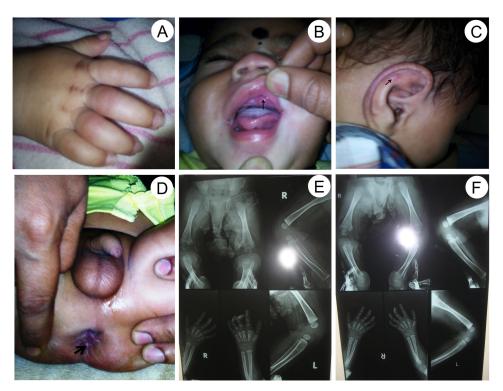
Images of different regions affected in infantile hyalinosis in identical twins. (A) showing Progression of joint contractures in the hand; (B) showing Gingival hypertrophy (Arrow mark); (C) showing Reddishness and papule over earlobe (Arrow mark); (D) showing Papular nodules in the perianal region (Arrow mark); (E) & (F) radiographs showing the joint contracture.
